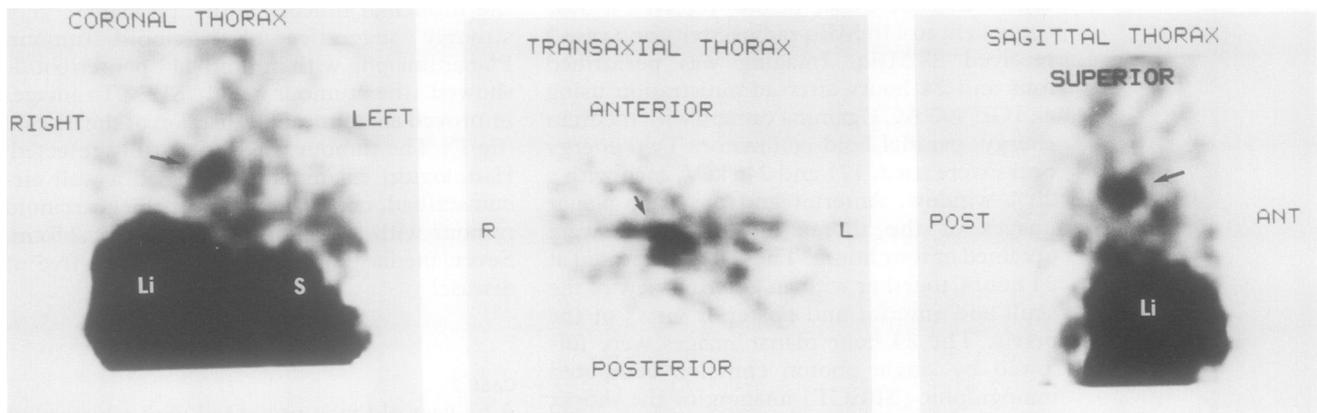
SPECT acquisitions of case 2 including a coronal image (anterior view through the tumour). The tumour is seen in the right lung, its position in keeping with the known site of disease in the bronchus intermedius. Non-specific uptake is seen in the liver (Li) and spleen (S).
